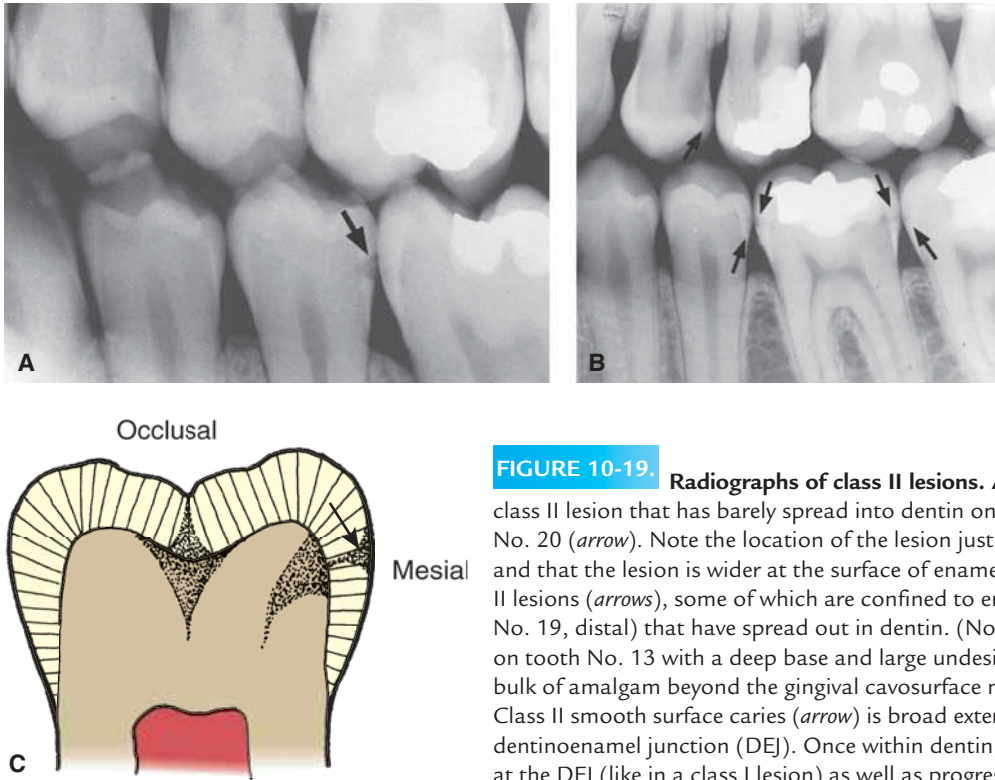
Radiographs of class II lesions. A. Radiographic evidence of a class II lesion that has barely spread into dentin on the distal surface of tooth No. 20 (*arrow*). Note the location of the lesion just cervical to the proximal contacts, and that the lesion is wider at the surface of enamel than at the DEJ. B. Several class II lesions (*arrows*), some of which are confined to enamel and two (No. 12 and No. 19, distal) that have spread out in dentin. (Note the existing class II amalgam on tooth No. 13 with a deep base and large undesirable overhang, that is, excess bulk of amalgam beyond the gingival cavosurface margin.) C. The spread pattern of Class II smooth surface caries (*arrow*) is broad externally, narrowing toward the dentinoenamel junction (DEJ). Once within dentin, this lesion spreads out laterally at the DEJ (like in a class I lesion) as well as progressing toward the pulp.
